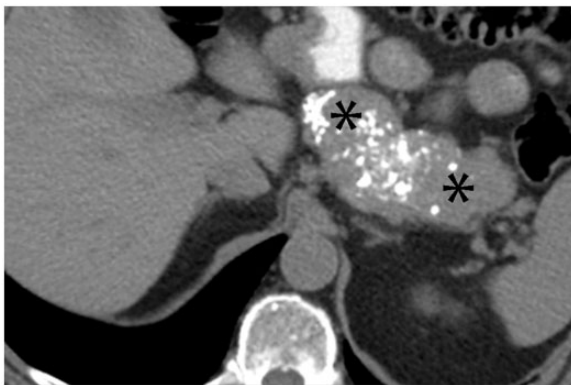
A 72-year-old man with pancreatic neuroendocrine tumor. Axial nonenhanced CT shows diffusely enlarged pancreatic body and tail (asterisks), with extensive calcification.
